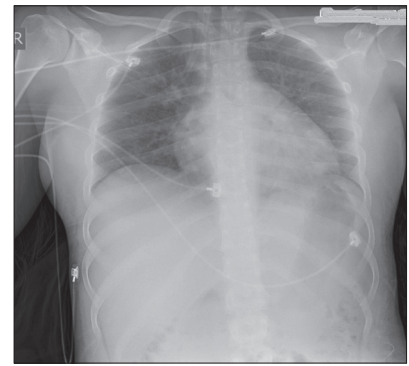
Chest radiograph 48 hours after immunoglobulin administration
